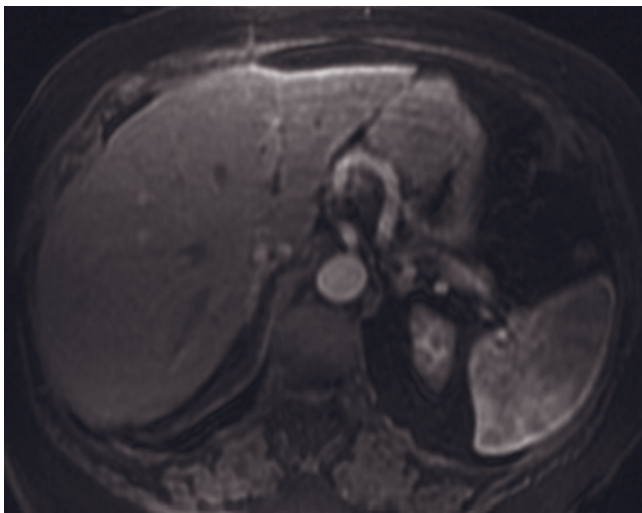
Gastric polyps. Immediate postgadolinium SGE (a) and 90-s postgadolinium fat-suppressed SGE (b) images in a patient with Gardner syndrome demonstrate multiple enhancing gastric polyps (arrows, a, b). The polyps possess intense enhancement. Gastric neurofibromas. T2-weighted single-shot echo-train spin-echo (c), T1-weighted SGE (d), T1-weighted postgadolinium hepatic arterial dominant-phase SGE (e), and T1-weighted postgadolinium fat-suppressed hepatic venous-phase SGE (f) images demonstrate neurofibromas (arrows, c, d) located in the cardia portion of the stomach. The lesions show heterogeneous high signal on T2-weighted image (c) and low signal on T1-weighted image (d). The lesions show negligible enhancement on postgadolinium images (e, f). Note that paravertebral neurofibromas (open arrows, c) are present. Gastric schwannoma. Coronal T2-weighted
